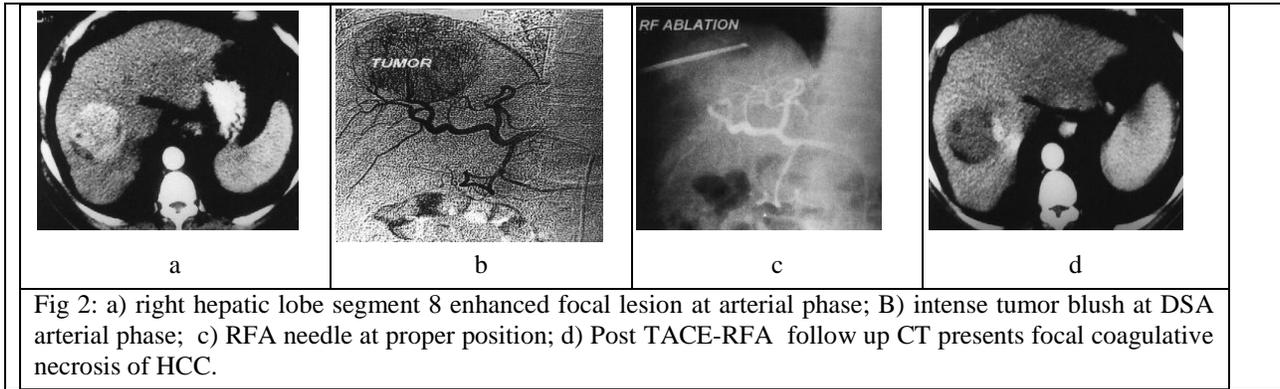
a) right hepatic lobe segment 8 enhanced focal lesion at arterial phase; B) intense tumor blush at DSA arterial phase; c) RFA needle at proper position; d) Post TACE-RFA follow up CT presents focal coagulative necrosis of HCC.
